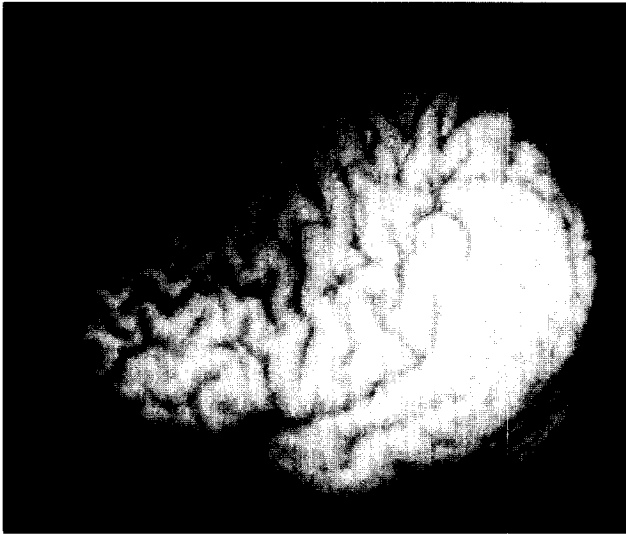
A surface rendered image of the cortical surface of the brain. The image is generated by first removing the skull and scalp from the raw MRI dataset and then rendering the image using an integrated shading method (Bomans et al., 1990).
